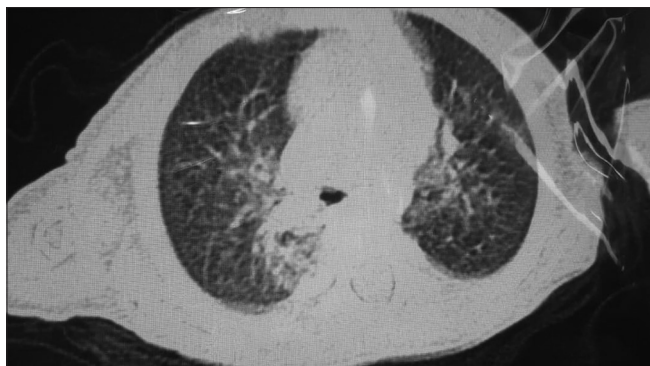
Chest computed tomography scan. Several opacity foci are in the apical segment of the lower lobe of both lungs
